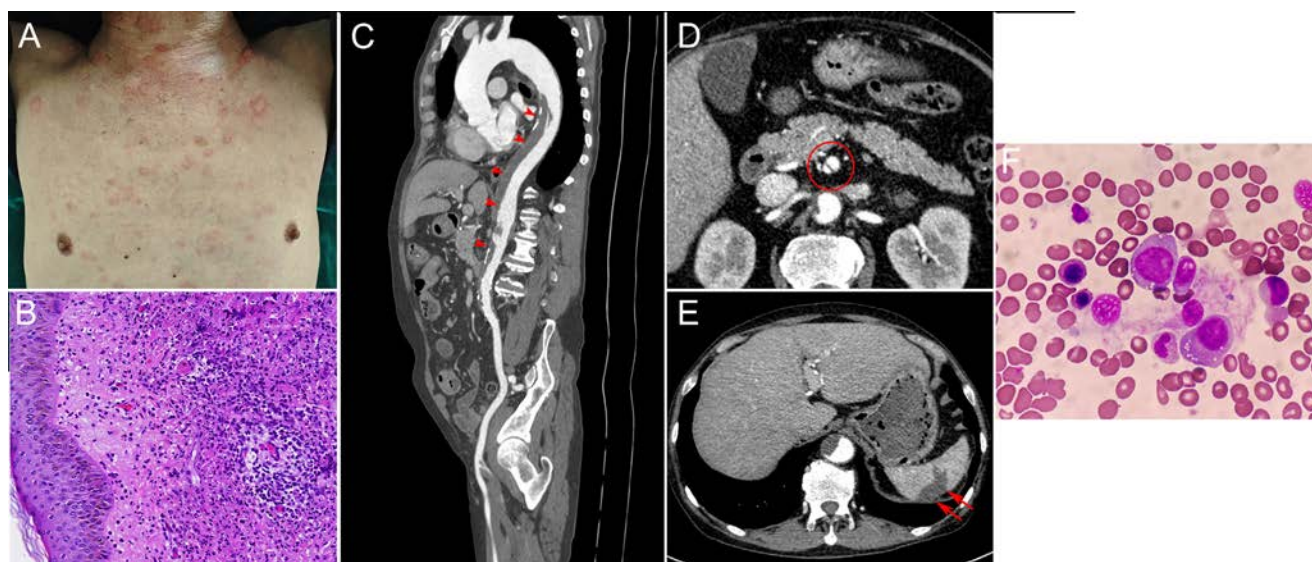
VEXAS syndrome with vessel complications and inflammatory manifestations. (A) Physical examination revealed erythematous plaques on the neck/thoracic region. (B) Skin biopsy showed inflammatory cell infiltration, predominantly composed of neutrophils, observed throughout the entire dermis and within the superficial subcutaneous adipose septa. (C) Curved planar reformation of aortic computed tomography (CT) angiography demonstrated a long-segment thrombus in the thoracoabdominal aorta (arrowhead). (D) Axial aortic CT angiography image revealed a dissection of the superior mesenteric artery with true and false lumina (circled). (E) Contrast-enhanced axial scan displayed a splenic infarction manifesting as a patchy, wedge-shaped hypoenhancing lesion (long arrow). (F) Bone marrow aspiration showed vacuolisation in myeloid precursors.
